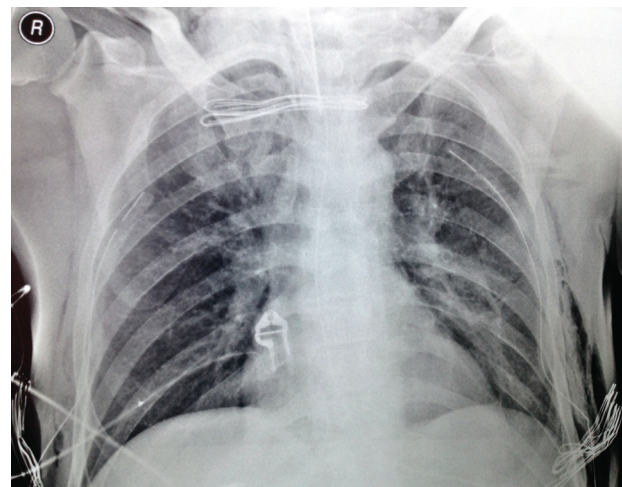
The chest X-ray shows the tube thoracostomies and the recovery of the collapsed lungs
